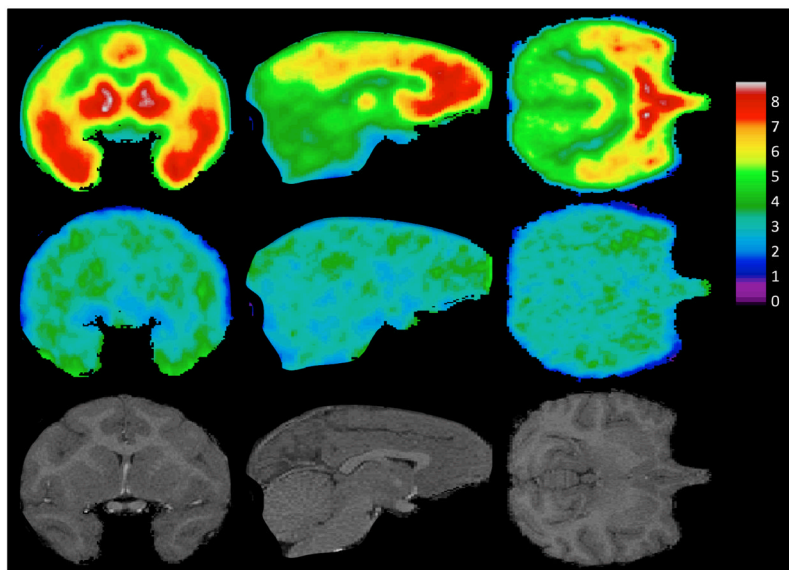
Mean PET images under normal (top row) and block (middle row) conditions, and Magnetic Resonance Images (bottom row)
